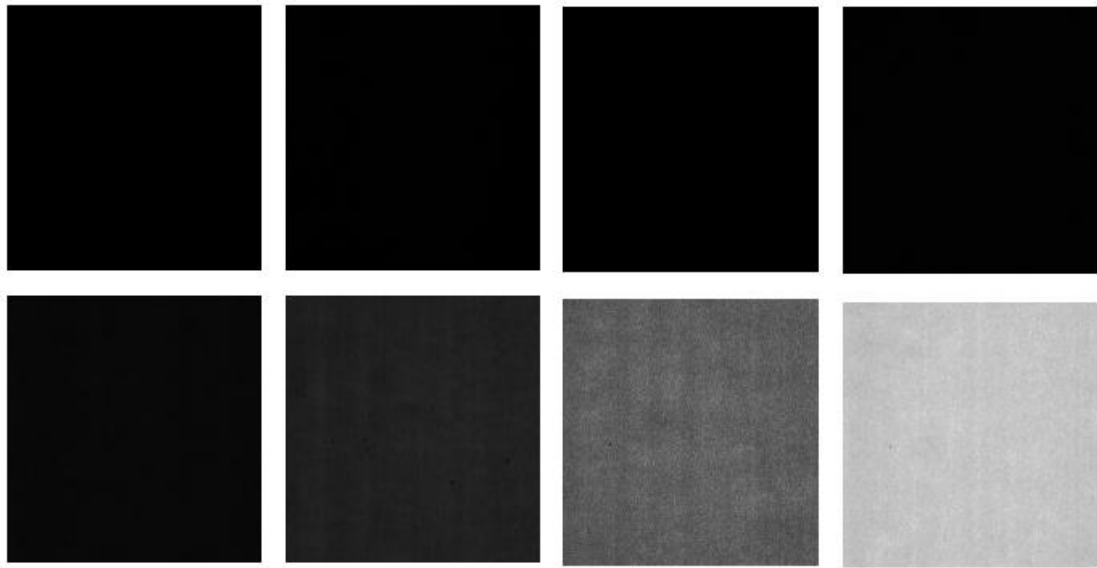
Sample of ladder from slide C14C15 used in density calculations, from left to right top to bottom (Shutter closed, black background of radiograph = 0mm, Level 1 = 0.02mm, Level 2 = 0.04mm, Level 3 = 0.06mm, Level 4 = 0.08mm, Level 5 = 0.1mm, and Level 6 = 0.12mm respectively)
